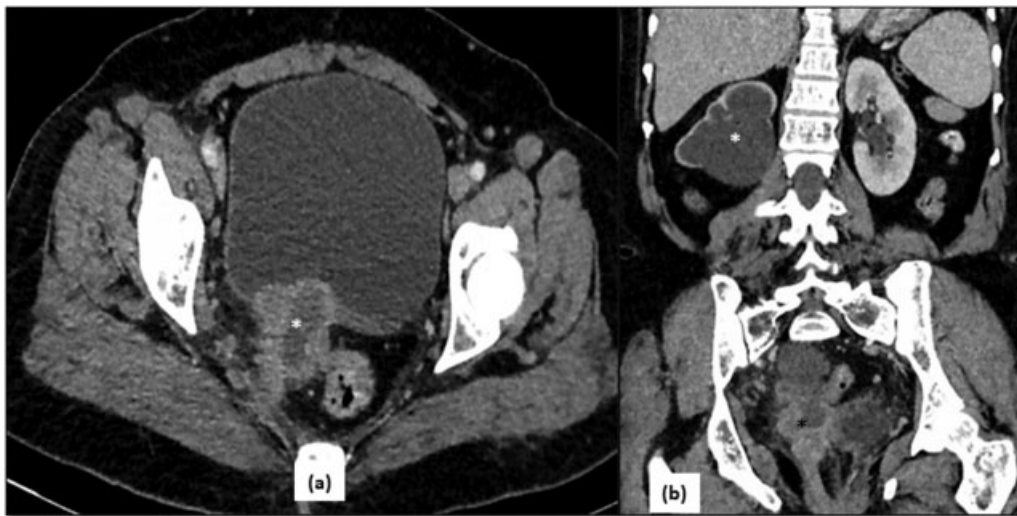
CT in stage IVA of carcinoma cervix—(a) Axial CT image shows an irregular heterogeneous mass in the cervix with central necrosis (asterisk in a) infiltrating the urinary bladder anteriorly and reaching up to the lateral pelvic wall posterolaterally on the right side. (b) There is upstream right hydronephrosis (white asterisk) due to encasement of lower ureter by the mass (black asterisk).
